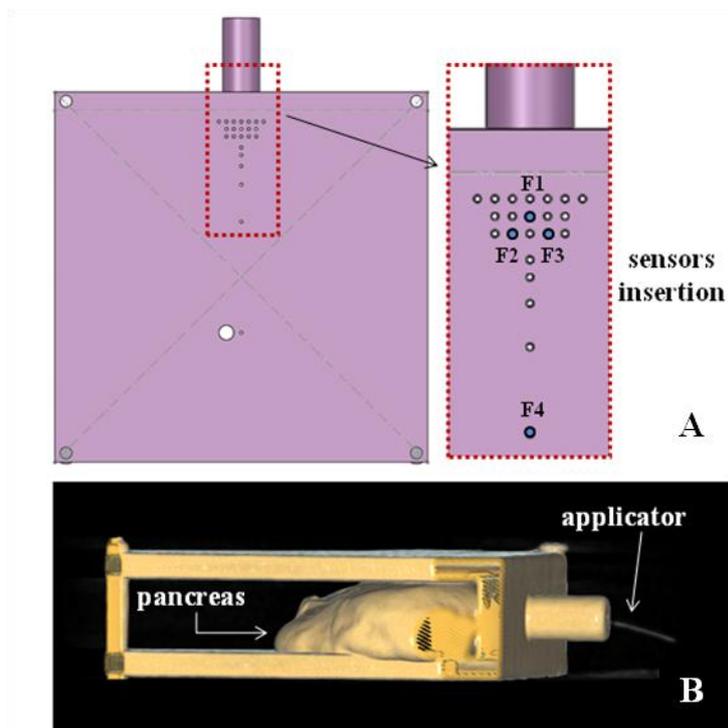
A) Arrangement of the four fibers inside the pancreas by means of the PMMA mask (top view of the mask); B) CT scan image of the pancreas undergoing treatment.
